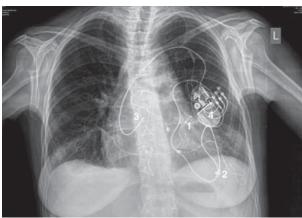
X-ray of implanted device
